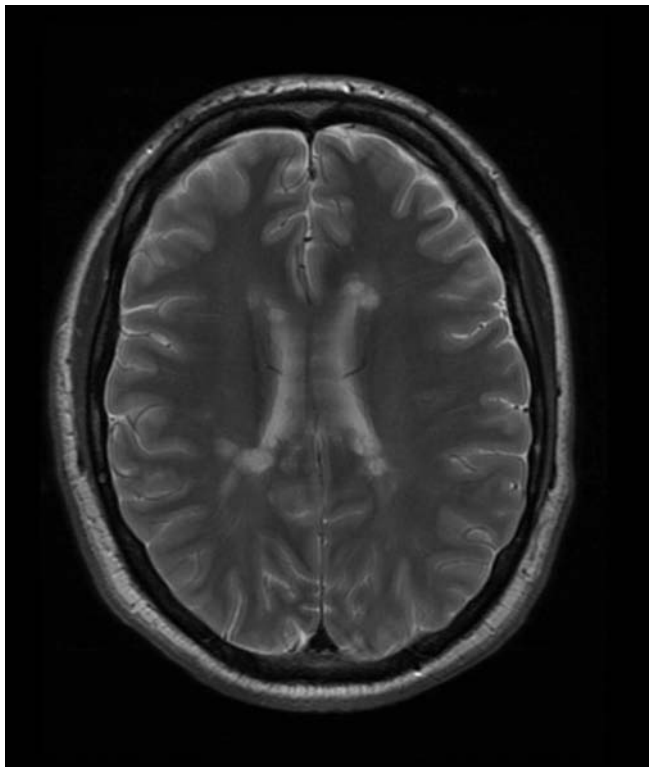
T2 weighted magnetic resonance imaging brain scan showing typical ovoid, periventricular multiple sclerosis lesions.
